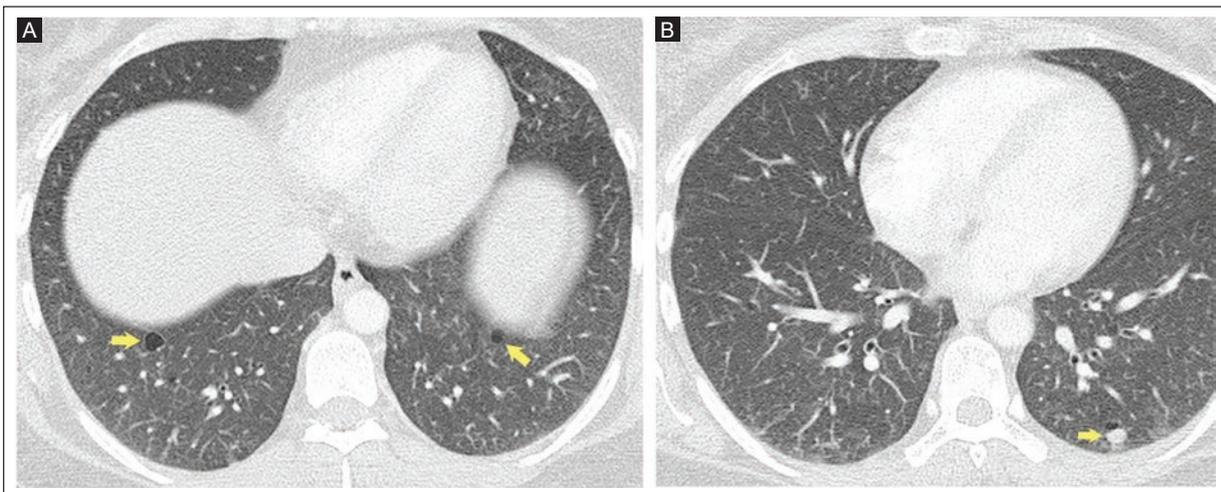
Cystic amyloidosis. Chest CT, axial view. A: thin-walled cysts in the lower lobes (arrows). B: same patient with a solid nodule in the left lower lobe (arrow).
